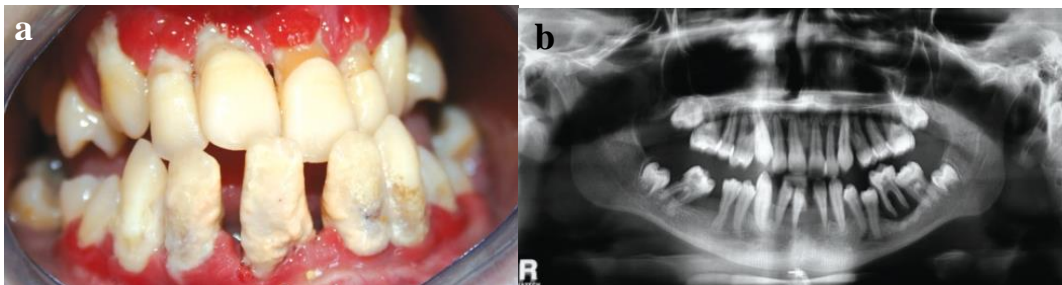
Dental symptoms of a patient with Haim-Munk syndrome. (a) The gingiva around the teeth is bright red, severely inflamed, swollen, with pus exuding from the periodontal pockets and gingival abscesses. (b) The panoramic radiographs shows severe vertical and horizontal alveolar bone loss around all remaining teeth (Erciyas *et al.*, 2010).
